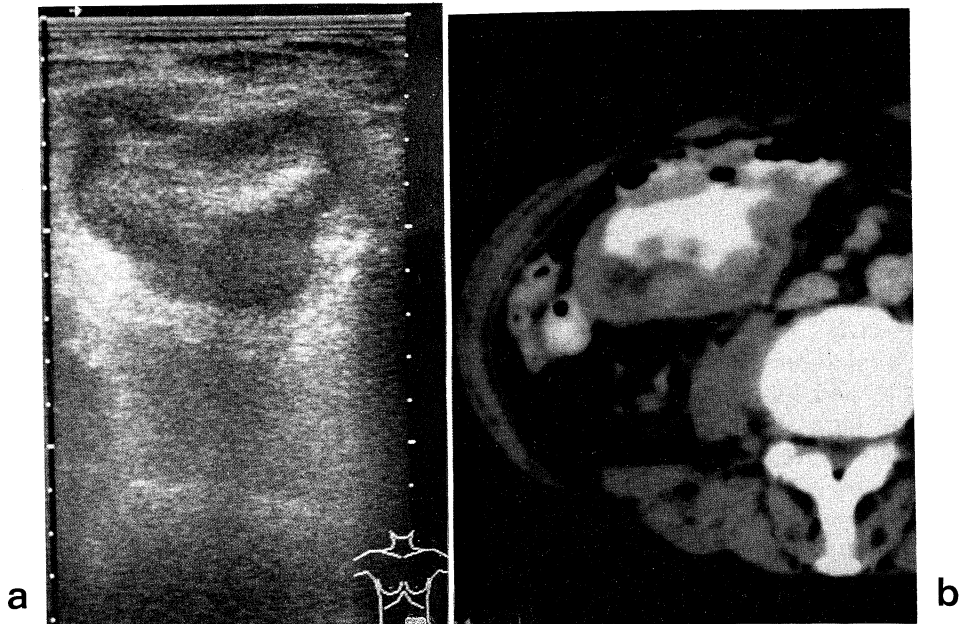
a: An abdominal ultrasonogram shows a pseudokidney shadow.
